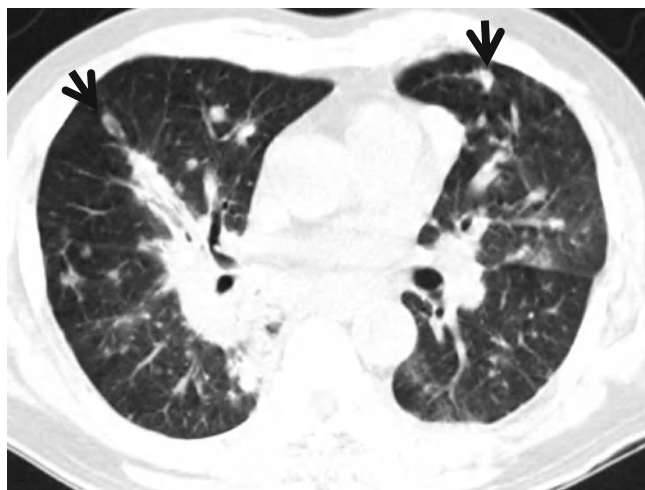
Lymphomatoid granulomatosis in a 70-year-old man showing reversed halo sign. Lung window image of CT scan (5.0-mm section thickness) obtained at level of the left lower lobar bronchus shows multiple variable-sized nodules in both lungs. Please also note bilaterally enlarged hilar lymph nodes. Some nodules show reversed halo sign (arrows)
